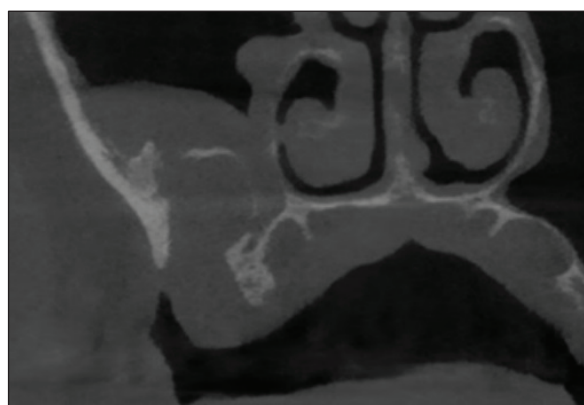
Cross-sectional cone beam computed tomography (CBCT) image – frontal plane view.
